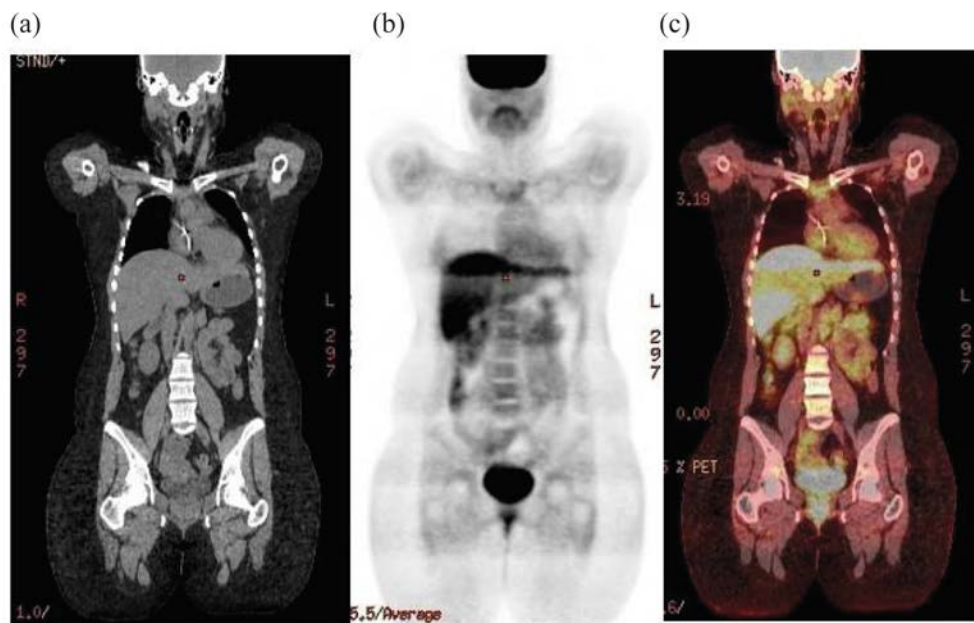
Coronal CT (a), FDG-PET (b) and fused PET/CT (c) images acquired in 3-D and reconstructed without correction for the slice to slice axial sensitivity profile. The increased axial width of the artefact in 3-D compared to 2-D in Fig. 3.17 should be noted.
